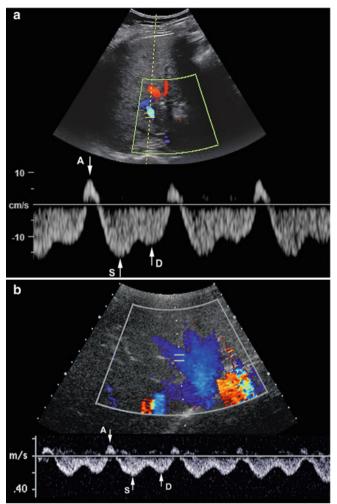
Hepatic vein waveforms. (a) and (b) Color and spectral Doppler of the hepatic vein, demonstrating normal multiphasic flow with the A-wave (*arrow*, *A*), S-wave (*arrow*, *S*), and D-wave (*arrow*, *D*). The V-wave, defined by some as a separate wave, is the depression between the S- and D-waves
